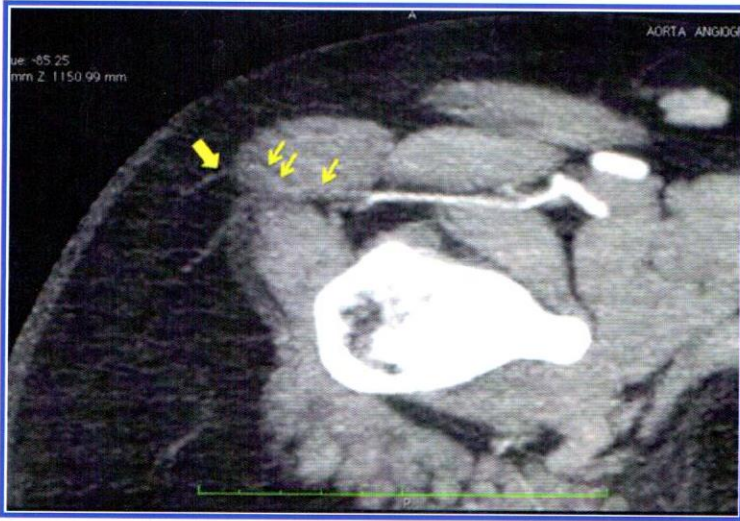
CT angiography, axial reformatted multi-planar reformatted (MPR) image showing the intramuscular (small arrows) and subcutaneous (large arrow) course of the perforator.
